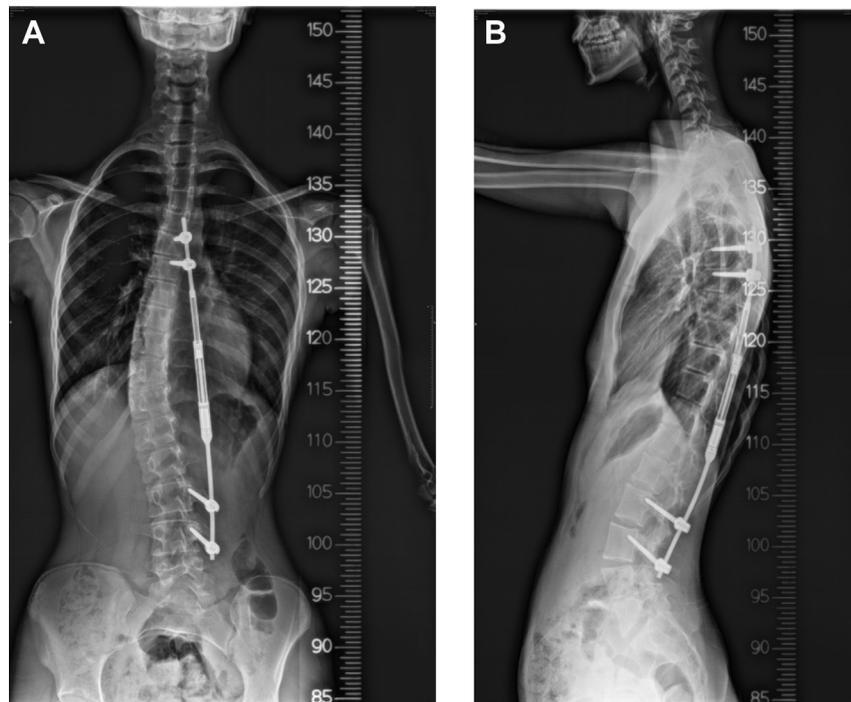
Antero-posterior (A) and lateral (B) X-ray of a 9 year old patient with a single magnetic rod after the last distraction.
